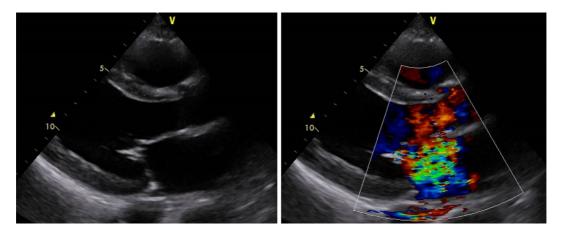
Echocardiography. The ejection fraction was 20% with diffuse hypokinesis and severe mitral regurgitation.
